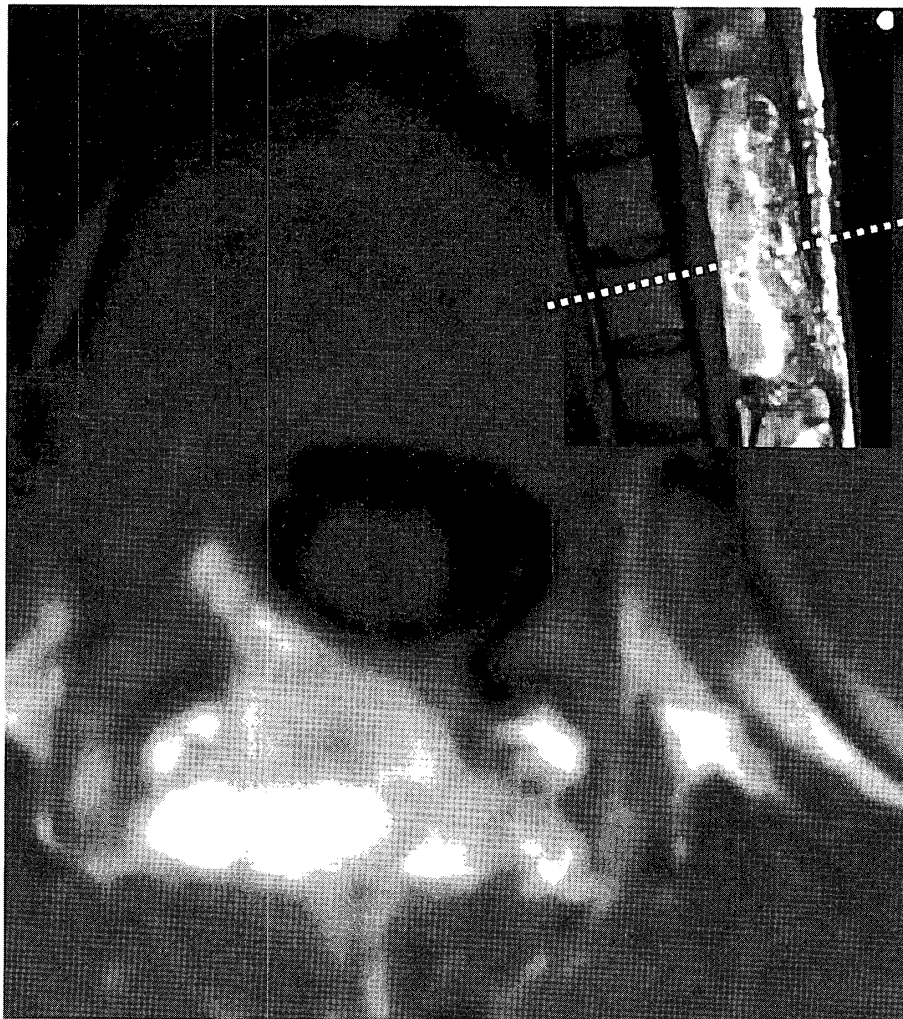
Postoperative MRI demonstrated that both the cystic lesion and spinal cord compression had disappeared.
